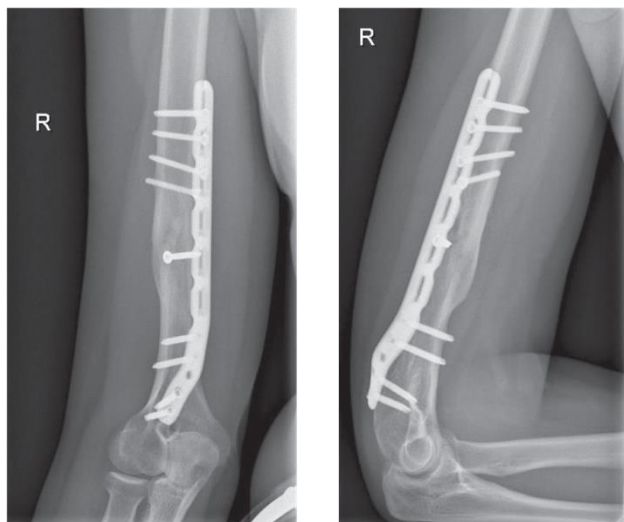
X-ray images of patient B., front and lateral views. The consolidation of a fracture of the right humerus after osteosynthesis
